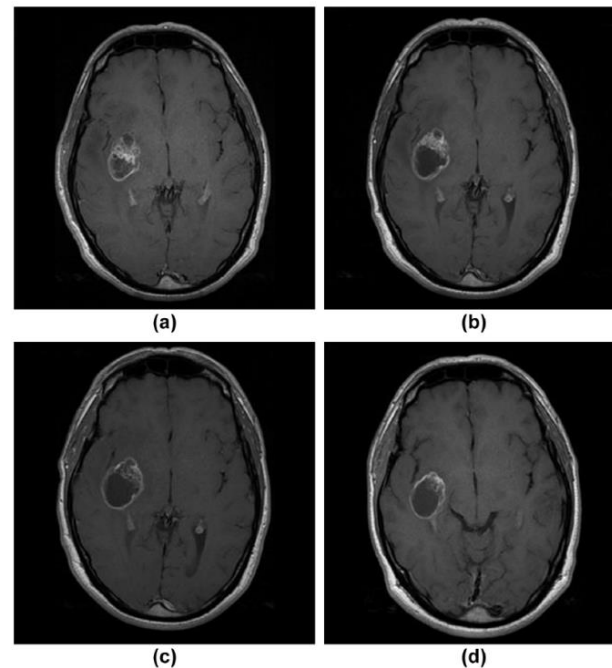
A patient with GBM. (a) Post-surgical MRI image showing progression on MRI at (b) 1 months and (c) 4 months post-radiotherapy; at stabilisation at (d) 7 months post-radiotherapy indicating pseudoprogression.
